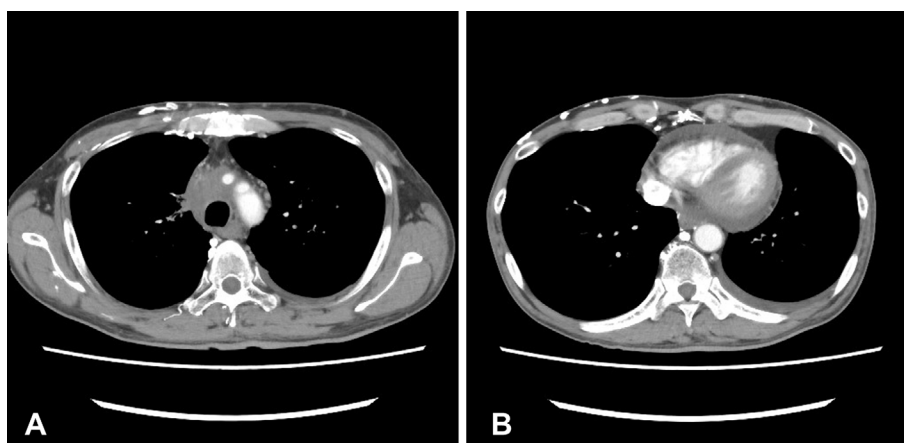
(A, B) Contrast-enhanced CT performed two months after radiotherapy revealed shrinking of the tumor in the right upper lobe and mediastinal lymph node. SVC obstruction and small amounts of pericardial and pleural fluids remained.
